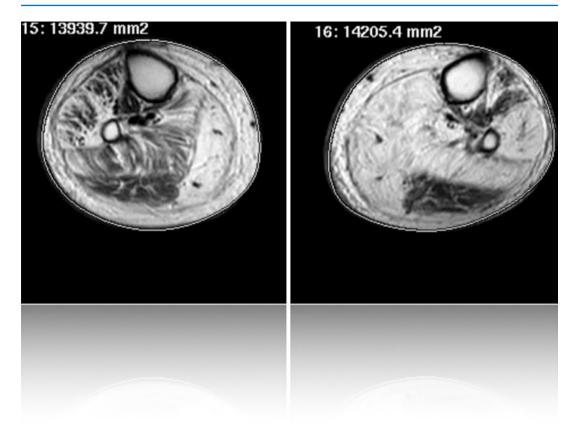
This patient presented with bilateral lower extremity swelling, but MRI showed complete fatty degeneration of his musculature which was the real cause of his limb swelling
